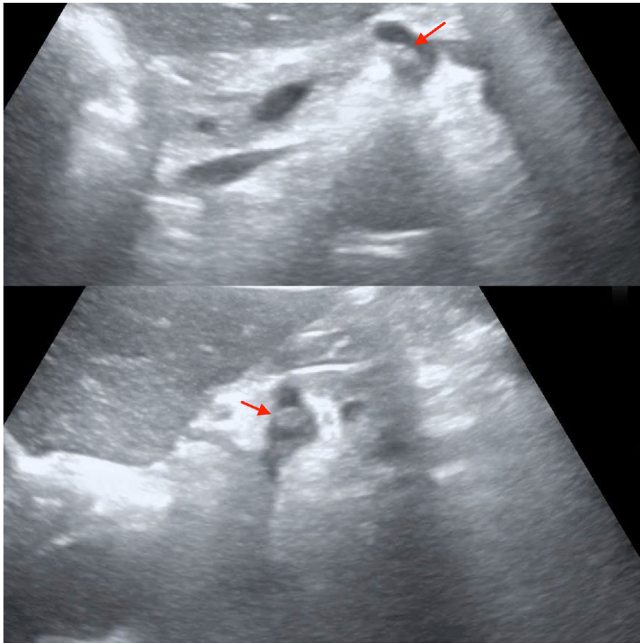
Ultrasound image showing a mural thrombus (red arrow) in the celiac artery in the top, transverse orientation and in the bottom, sagittal orientation.
